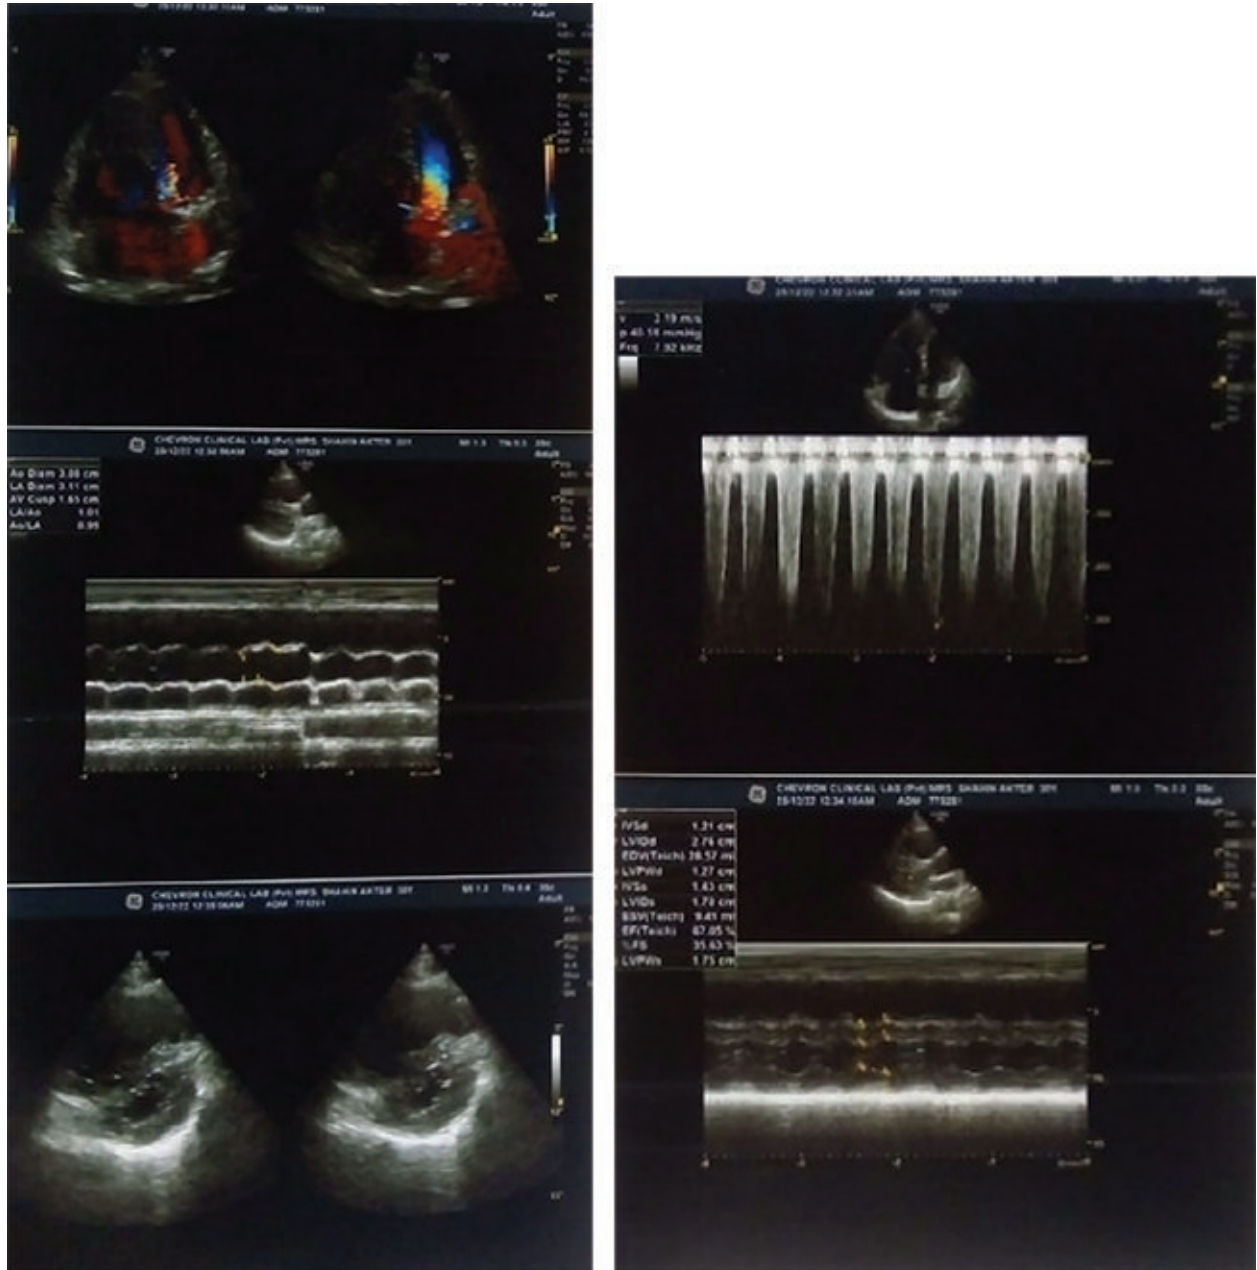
Two-dimensional and m-mode Echocardiography suggestive of pulmonary hypertension
